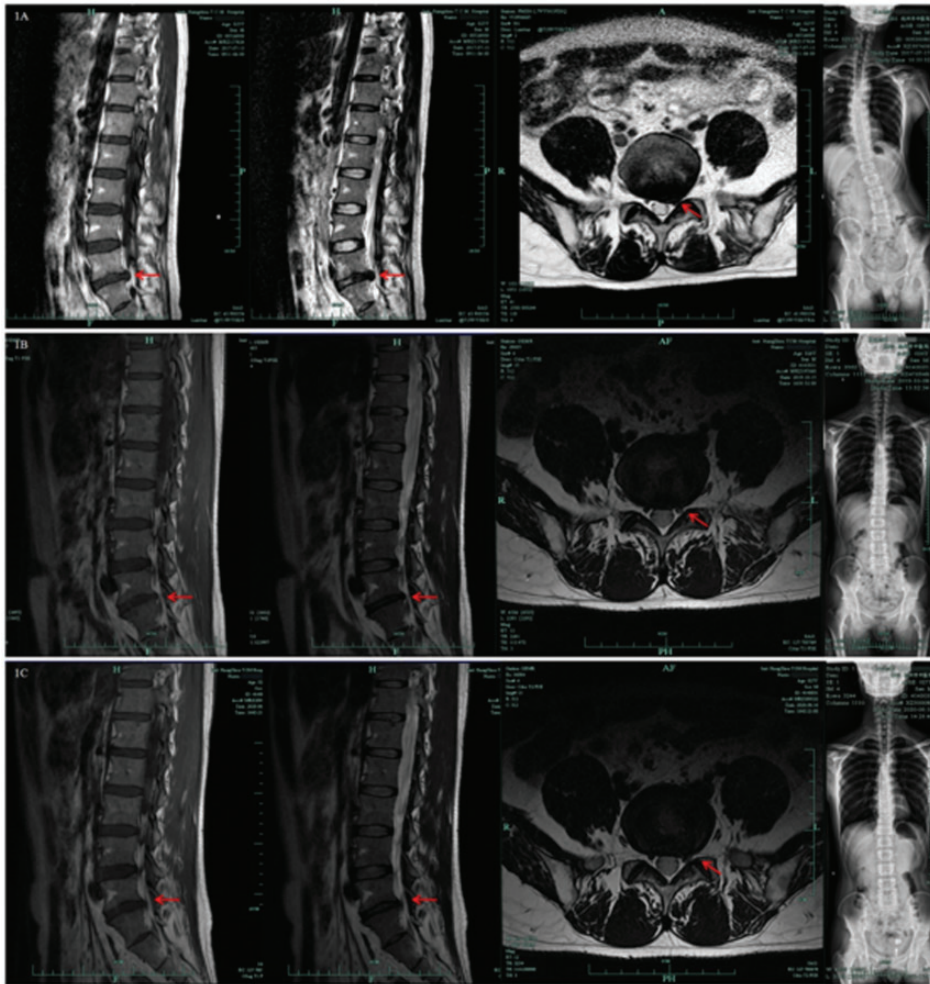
Axial and sagittal T1-weighted and T2-weighted magnetic resonance images (MRI) of the lumbar spine and radiographs of the entire spine. (a) Disc herniation at L5/S1 compressing the traversing S1 nerve roots (arrows) in July 2017 accompanied by significant scoliosis; (b) Significant resolution of the herniation 2 years later (arrows), in October 2019, with mild scoliosis; (c) No appearance of new herniation 3 years later (arrows), in June 2020, with no scoliosis.
